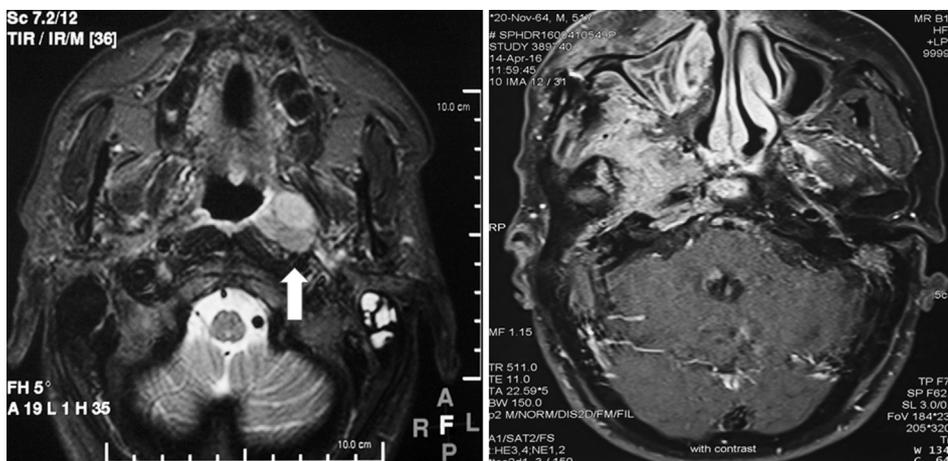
(Left) Axial view of MRI showing recurrent NPC on the left side with invasion of the ipsilateral parapharyngeal space, abutting the left cervical segment of the ICA (white arrow). The left lateral pterygoid muscle is intact and spared from tumour invasion. (Right) Axial view of MRI showing extensive tumour invasion of the right infratemporal fossa.
